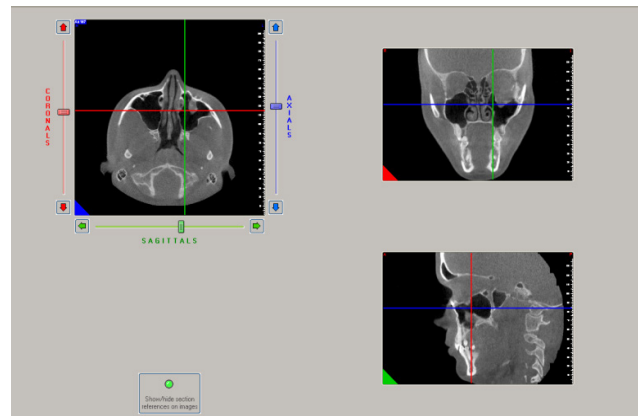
CBCT. MPR representation in the three planes of the head.
